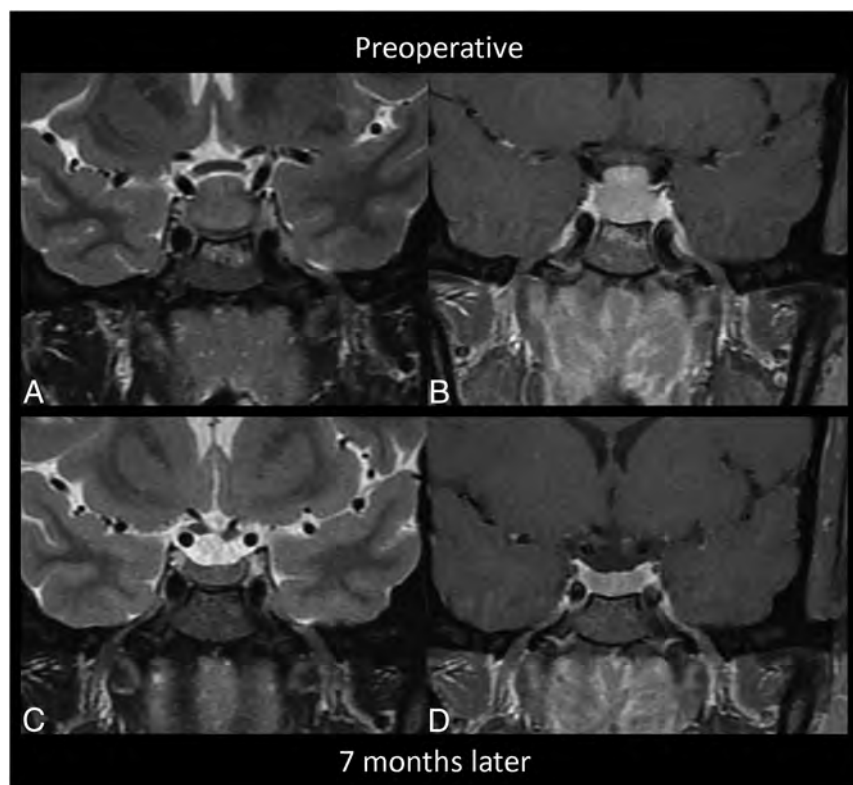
MR images of patient 3 with secondary GH from sarcoidosis. These show preoperative edema (A, coronal T2-weighted image) and enhancement (B, postcontrast coronal T1-weighted image) of the infrasellar basisphenoid bone marrow. After biopsy and oral dexamethasone, follow-up imaging 7 months later shows resolution of the edema (C, coronal T2-weighted image) and enhancement (D, postcontrast coronal T1-weighted image) with a decreased size of the pituitary mass.
